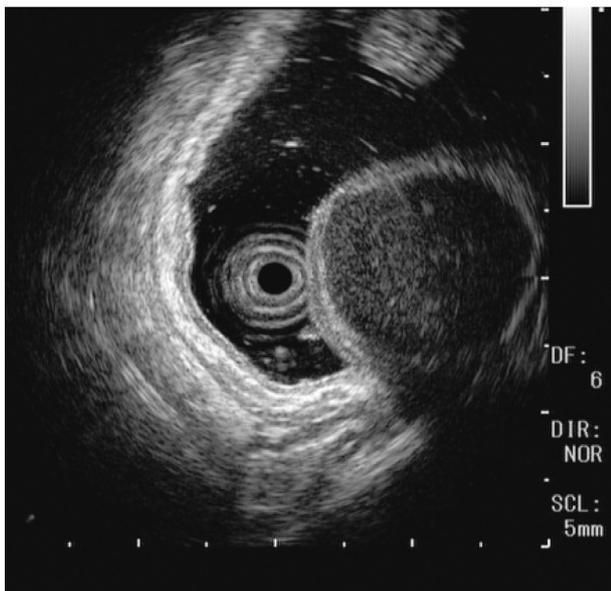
Endoscopic ultrasonography showing a hypoechoic lesion in the third to the fourth layer.
